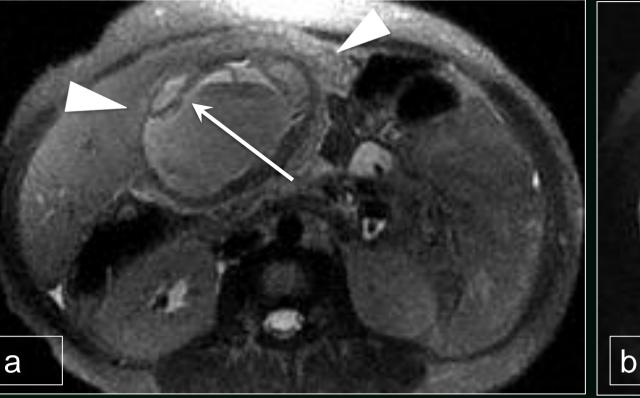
Gangrenous gallbladder. Axial T2-weighted SSFSE images exhibit gallbladder wall thickening, intramural fluid-fluid levels, mural perforation (black arrow), and pericholecystic edema (white arrowheads). At gallstone (white arrow) was identified in the fundus.
